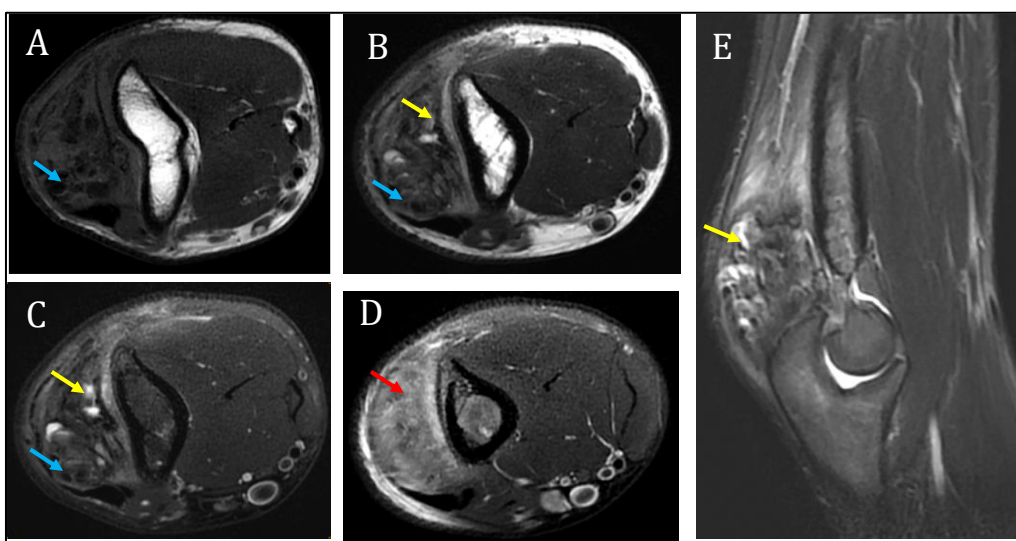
Right elbow MRI: Axial T1 (A); Axial (B, C, D) and Sagittal (E) T2 Short Tau Inversion Recovery (STIR): Well-demarcated extraosseous soft tissue mass along the lateral aspect of the elbow, abutting the proximal radius and ulna, with heterogeneous intensity, showing ring-like calcifications (low signal intensity on T1- and T2- weighted images, blue arrows). There is a central intralesional high signal on T2 related to chondral matrix (yellow arrow). Note the absence of continuity of the mass with bone structures. There is T2 intermediate high-intensity among the triceps brachii muscle, consisting of oedema (red arrow)
